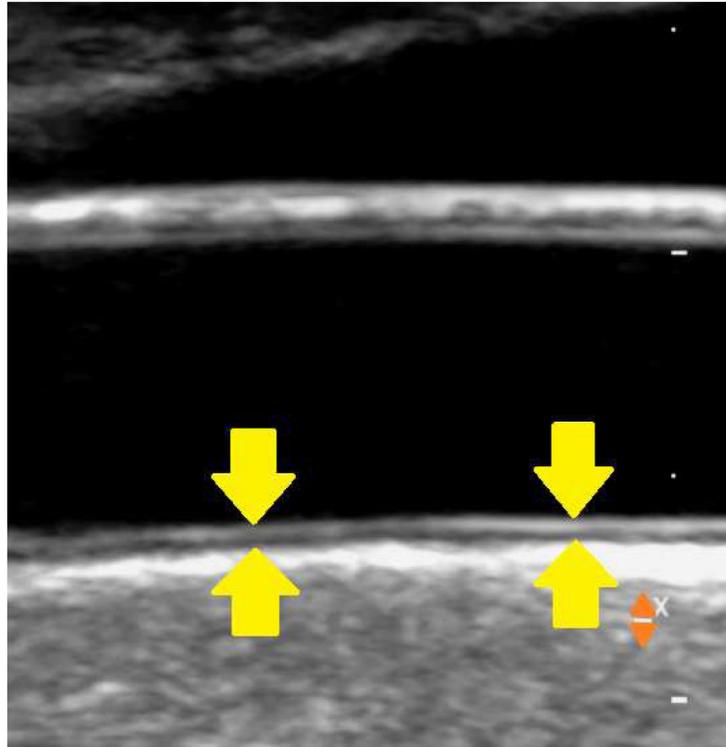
Common carotid artery ultrasound
